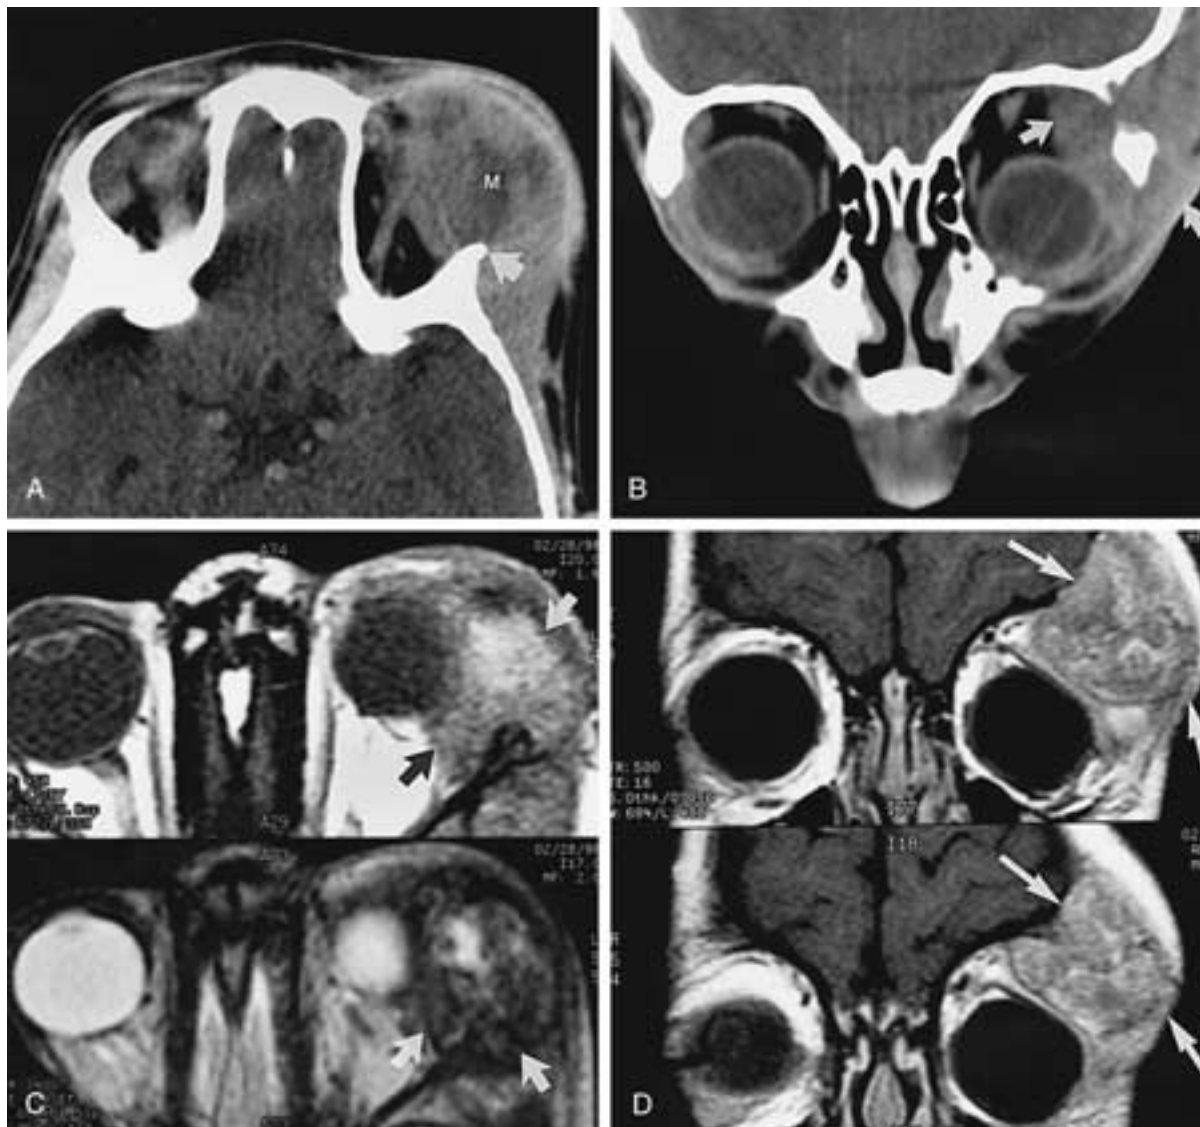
Langerhans' cell histiocytosis. A, Enhanced axial CT scan shows a prominent soft-tissue mass (*M*) with destruction of the orbital wall (*arrow*). B, Enhanced coronal CT scan shows a destructive mass involving the superolateral orbit (*arrows*). C, Axial proton-weighted (*top*) and T2-weighted (*bottom*) MR images show the mass (*arrows*). The mass appears hypointense on T2-weighted MR images caused by recent traumatic hemorrhage confirmed at surgery. D, Gadolinium contrast-enhanced, coronal T1-weighted MR images show marked enhancement of the lesion (*arrows*). (From Hidayat AA et al. Langerhans' cell histiocytosis and juvenile granuloma of the orbit. *Radiol Clin North Am* 1998;36:1229–1240.)
